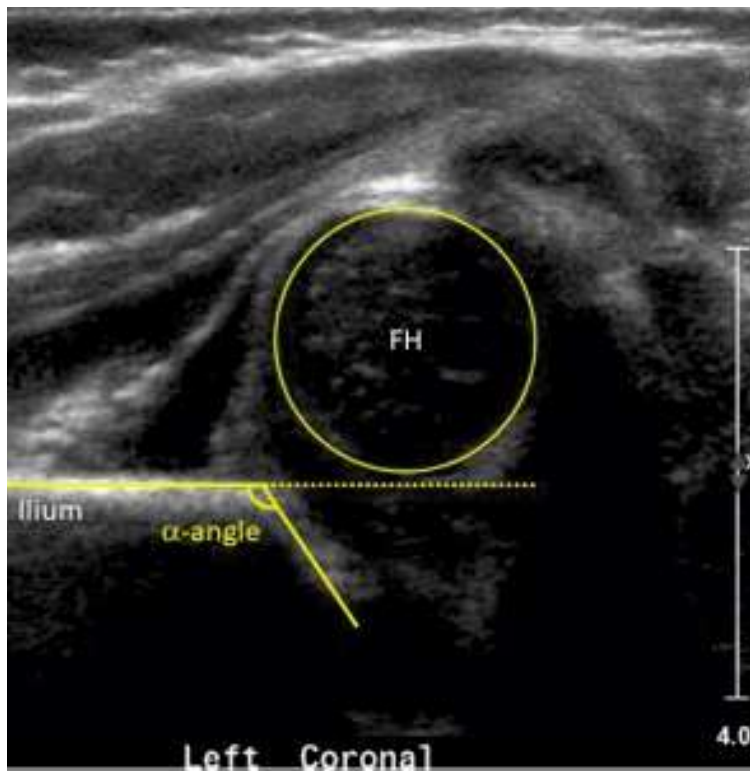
Ultrasound image demonstrating a complete hip dislocation. Note that the femoral head is normally bisected by a line drawn from the ilium (dotted line), but in this case, the femoral head (FH) is completely uncovered.
